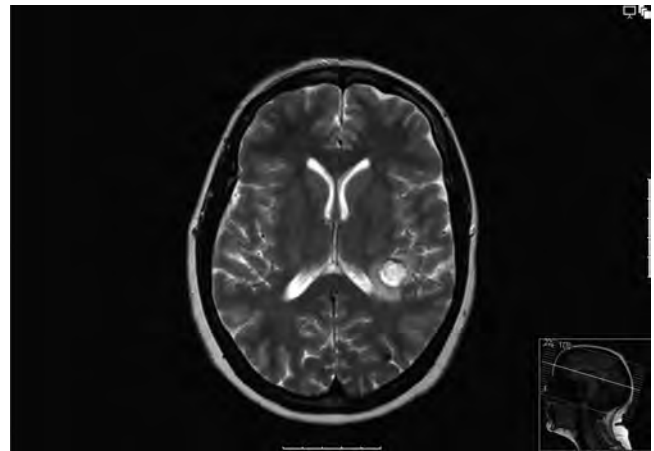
MRI T2 axial flare image showing left temporal lobe CCM with haemorrhage.
